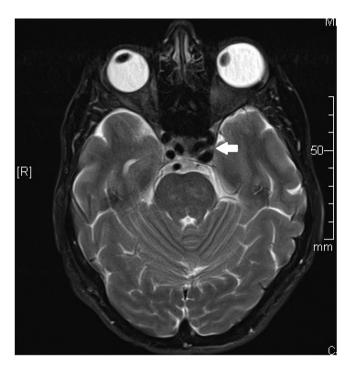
Magnetic resonance imaging in axial T2 fat suppressed with gadolinium demonstrating bilateral, left greater than right, cavernous sinus carotid vascular ectasia, (white arrow).
